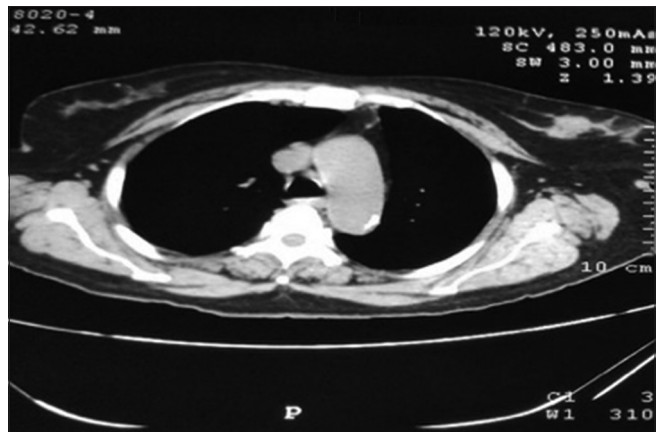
Contrast-enhanced computed tomography of chest showing well circumscribed hypodense lesion with mild peripheral enhancement in upper inner quadrant of the left breast
